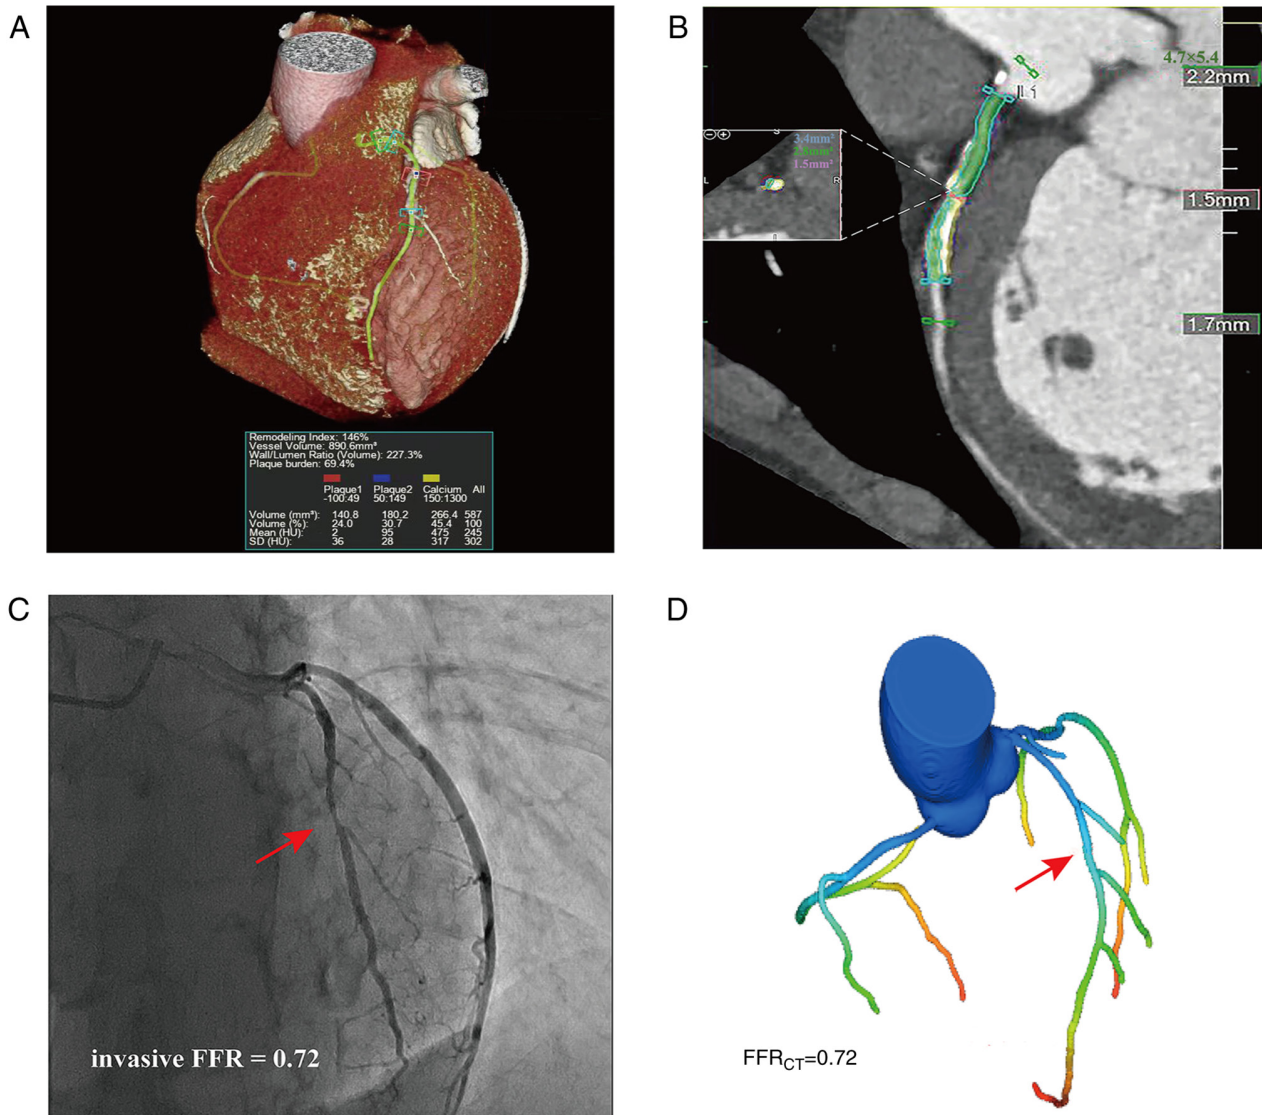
Case example of a 61-year-old male. (A) Coronary computed tomography angiography demonstrating a stenotic plaque of the LAD in a 3D imaging scan, revealing the mixed plaque composition of the proximal portion of the LAD: Calcified plaque, 266.4 mm³ (yellow); non-calcified plaque, 180.2 mm³ (blue); and low-density non-calcified plaque, 140.8 mm³ (red). (B) Color-coded semi-automatic plaque quantification of the lesion, as determined by (C) invasive coronary angiography, showing 50% stenosis of the LAD (red arrow), with the measured invasive FFR being 0.72. (D) Three-dimensional color-coding, revealing that FFR_{CT} in the distal LAD was 0.72. LAD, left anterior descending artery; FFR, fractional flow reserve; FFR_{CT}, computed tomography angiography-derived FFR; SD, standard deviation; HU, Hounsfield units.
